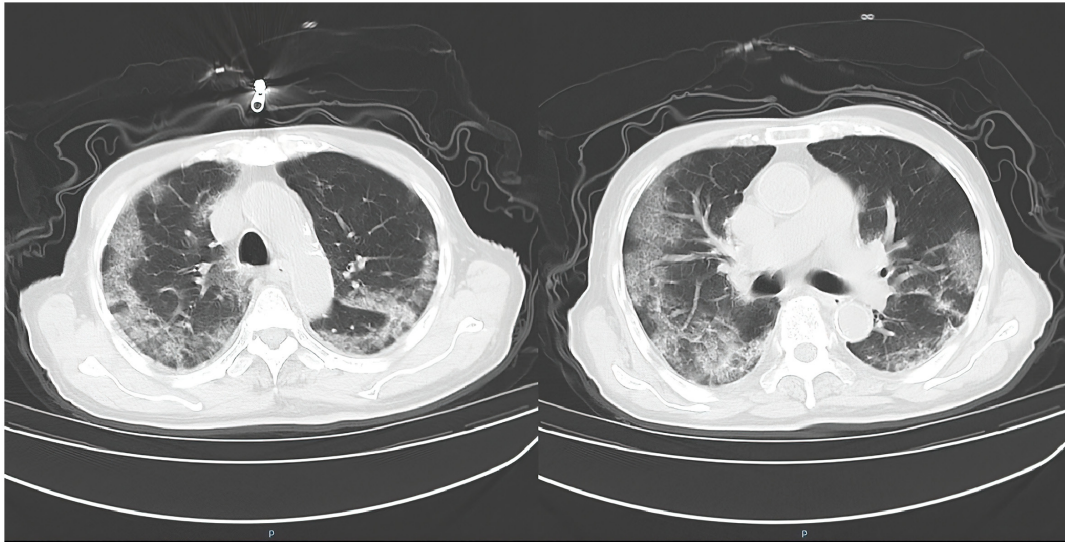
Computed tomography scans of the patient at different levels. Patchy fuzzy shadows with unclear boundaries and uneven internal density were observed in both lungs, especially in the lobus inferior pulmonis.
